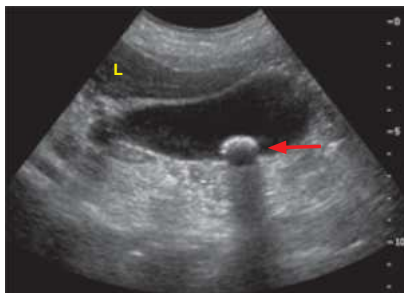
Cholelithiasis. Ultrasound image of the gallbladder shows a gallstone (*arrow*) with posterior shadowing. *L*, Liver. (Reproduced with permission from USMLE-Rx.com.)
